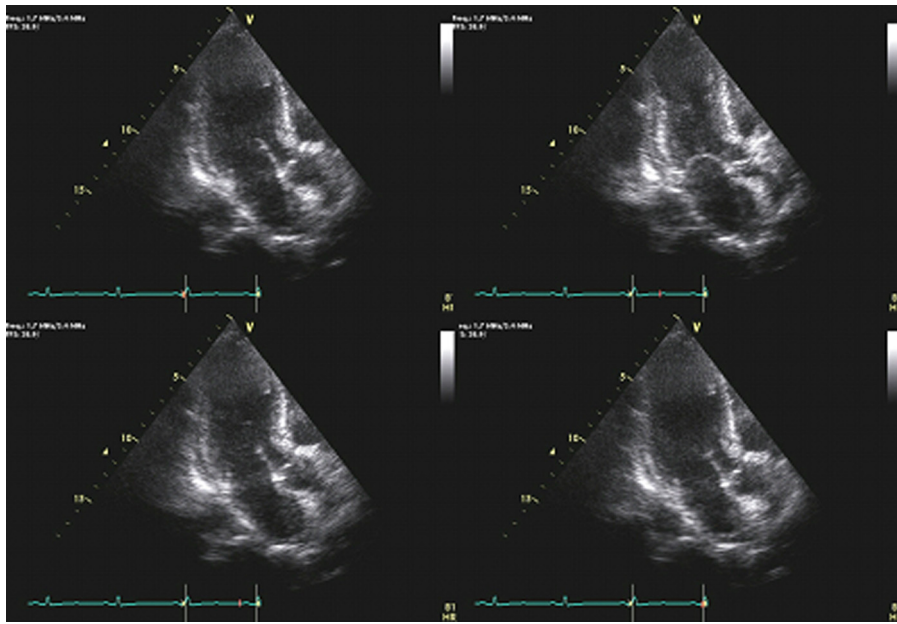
Second echocardiograph one week later showing typical form of apical ballooning was present in which the entire apical segments were akinetic.
